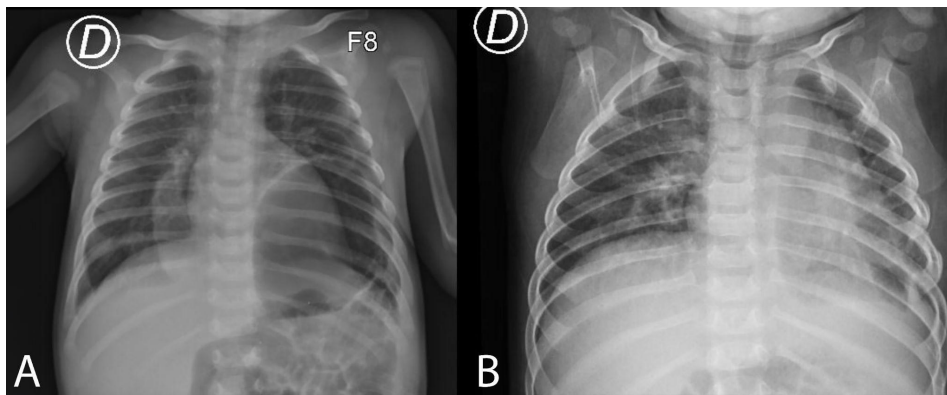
Chest X-rays in anteroposterior projection show in 1A an image suggestive of gastric chamber occupation in the left hemithorax compatible in the first instance with diaphragmatic hernia, and in 2B a control image is appreciated after a surgical procedure with the resolution of the CCAPM.
